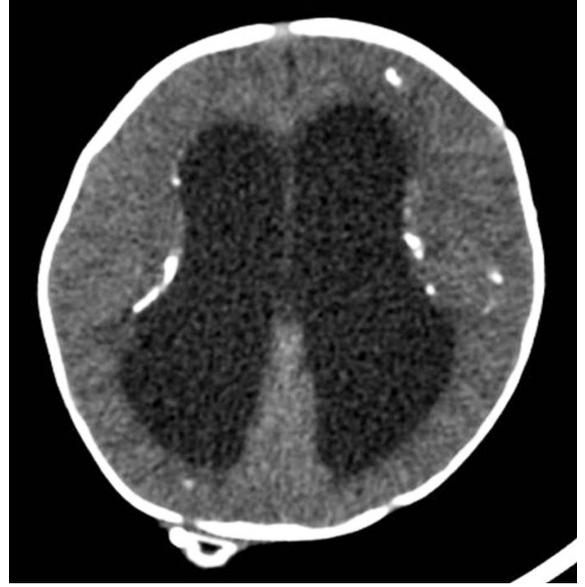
Ventricular catheter disappeared in the right ventricle on axial CT image.
